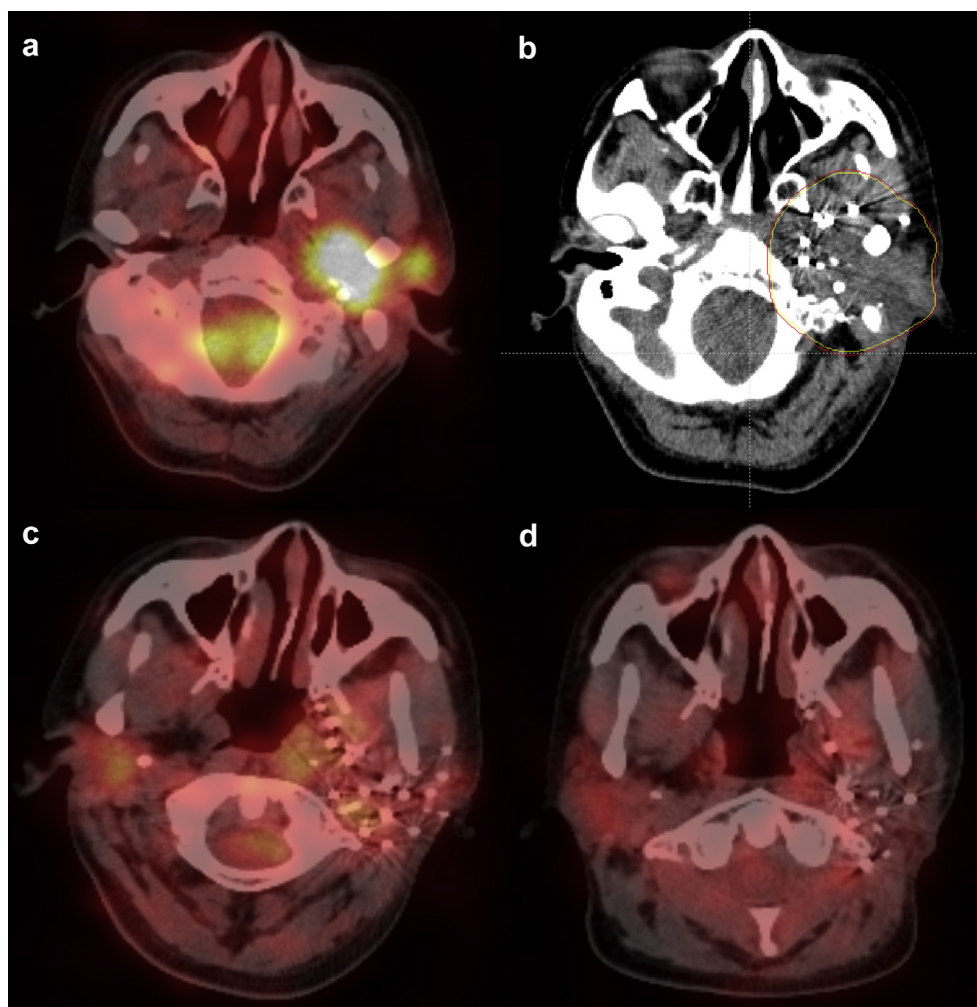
Preoperative PET/CT showed an unresectable parotid gland carcinoma (a). Quality verification using postoperative CT images in the brachytherapy treatment planning system showed that D_{90} curve cover the tumor area (b). PET/CT showed that the area of hypermetabolism regressed and inflammatory changes occurred around the area 6 months after brachytherapy (c). PET/CT showed no sign of recurrence 2 years after brachytherapy (d). PET/CT = positron emission tomography/computed tomography.
